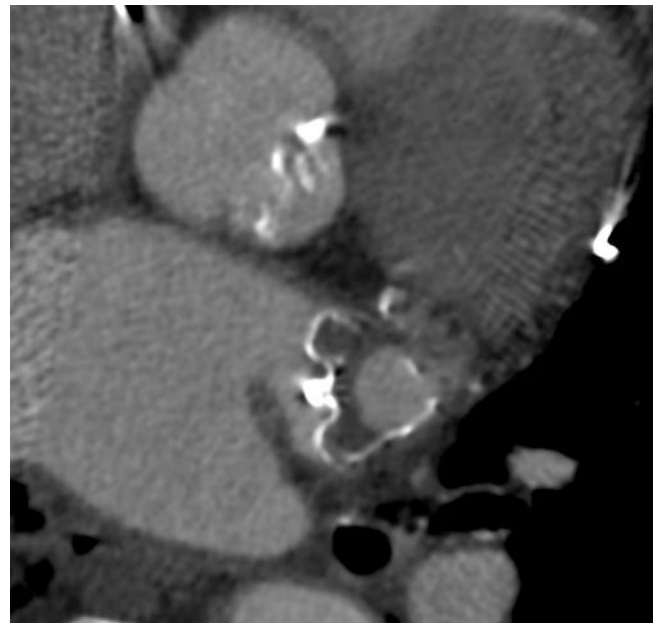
Redo PFO closure: CT multiplanar reformat image (a) demonstrates an Amplatzer septal occluder that was placed to close off a patent foramen ovale after a CardioSEAL occluder (b) failed. A volume-rendered image (c) shows both devices together
